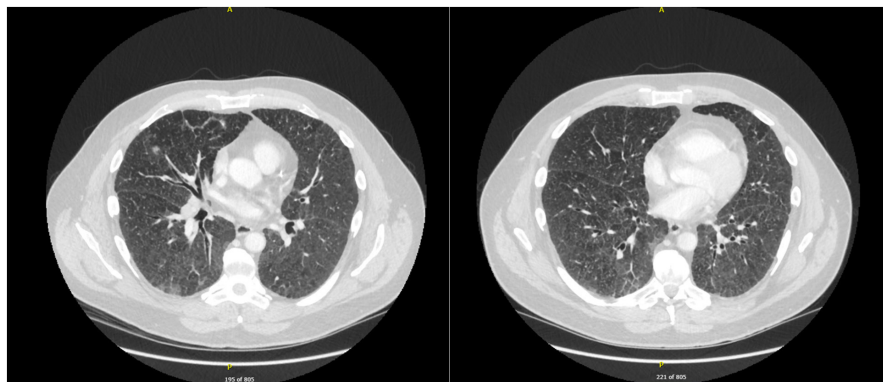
Imaging characteristics of the initial pulmonary abnormality presentation on computed tomography (CT) of the chest
